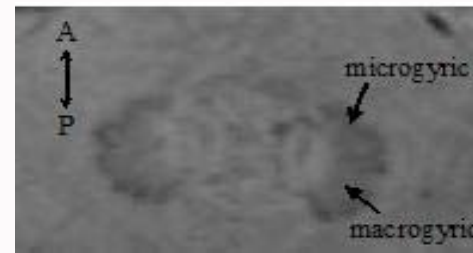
Axial Susceptibility-Weighted Imaging (SWI) 1.5 Tesla MRI sequence showing the microgyric and macrogyric regions of the dentate nucleus (source: Department of Neuroradiology, University Hospital of Montpellier).
